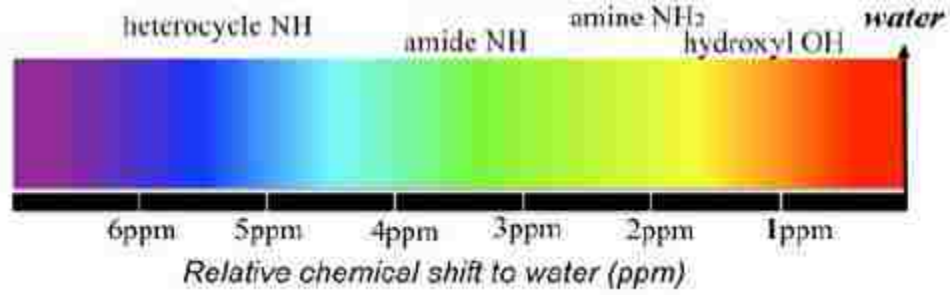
The chemical shifts of common solute protons for CEST-MRI *in vivo*. Adapted from Liu 2013.
